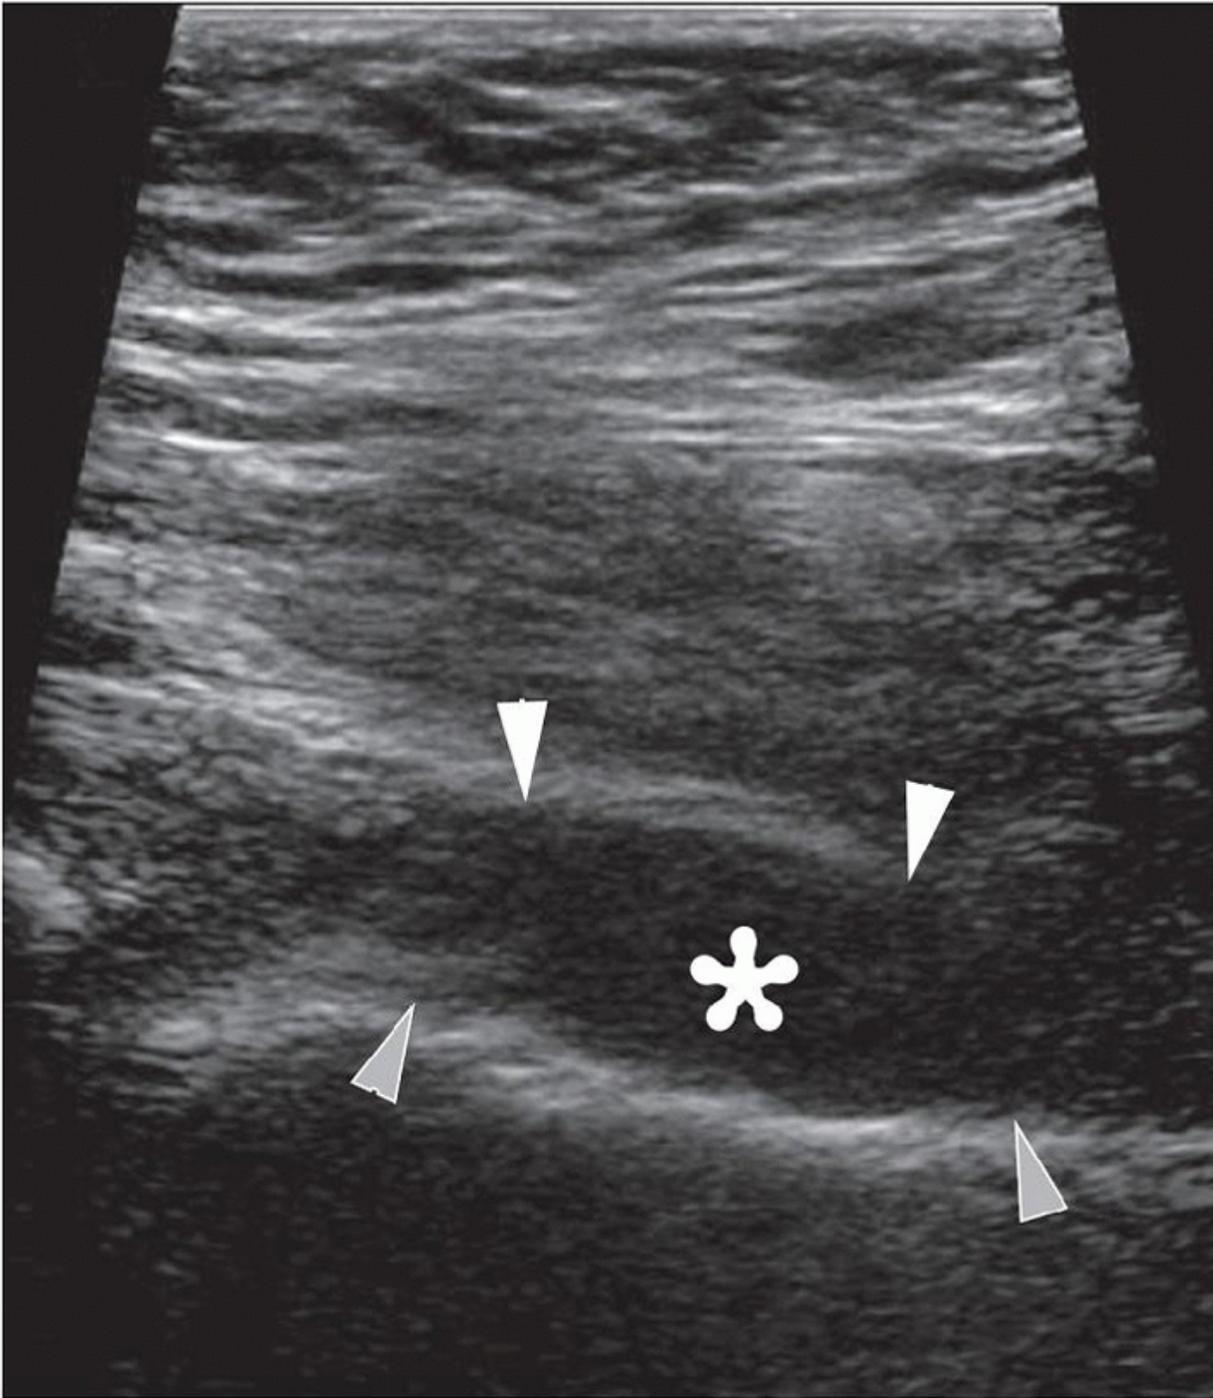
Hip effusion. Longitudinal sonogram shows anechoic hip effusion (asterisk) between the hyperechoic capsule (white arrowheads) and femoral neck (gray arrowheads).
